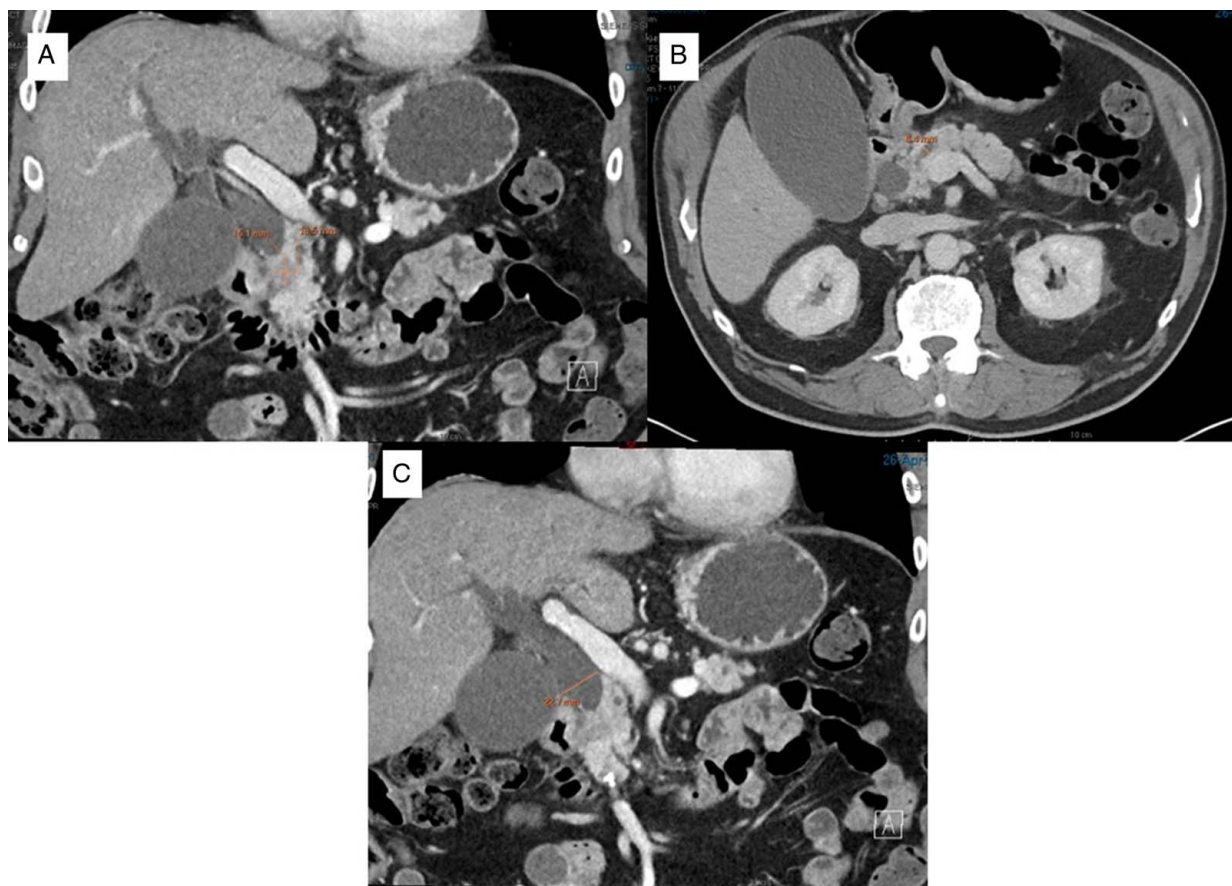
Case 2—Contrast-enhanced CT images demonstrating a pancreatic head mass measuring 15.1 × 13.5 mm without vessel contact (A). The MPD was 6.4 mm, and (B) the CBD measured at 22.7 mm (C). CT indicates computed tomography.
